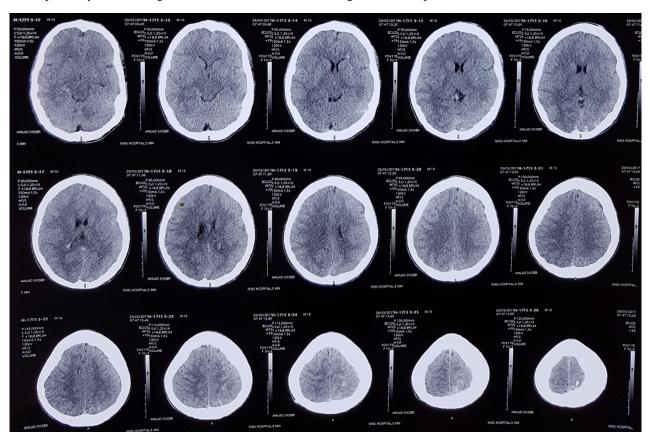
Computed tomography of head revealed left calvarial thickening with mild atrophy of left cerebral hemisphere
